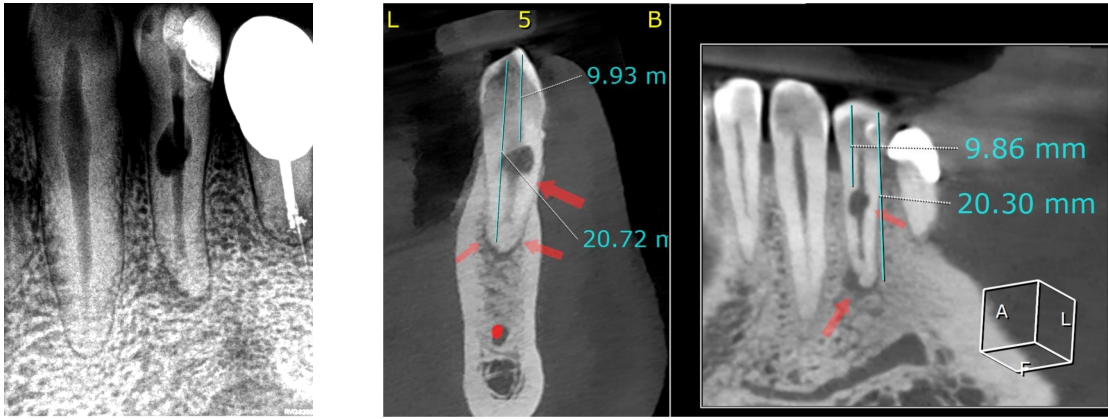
A) Preoperative periapical radiography and B) CBCT image of the tooth
